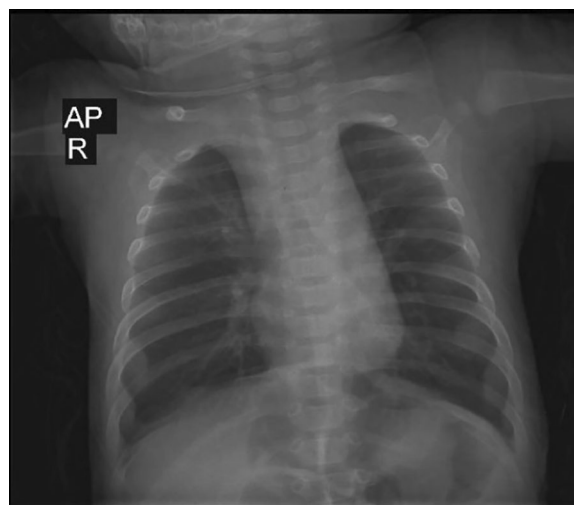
Postoperative chest X-ray of the patient, performed to rule out situs inversus and malrotation
